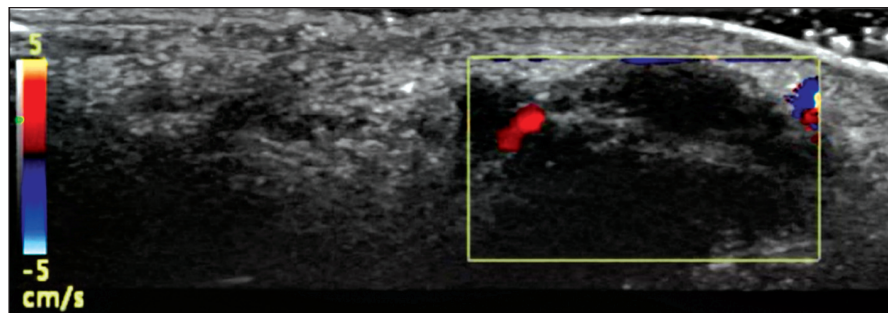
Sonogram of the lesion of the second finger of the hand. Color Doppler mapping mode. Single blood flow signals in the lesion
